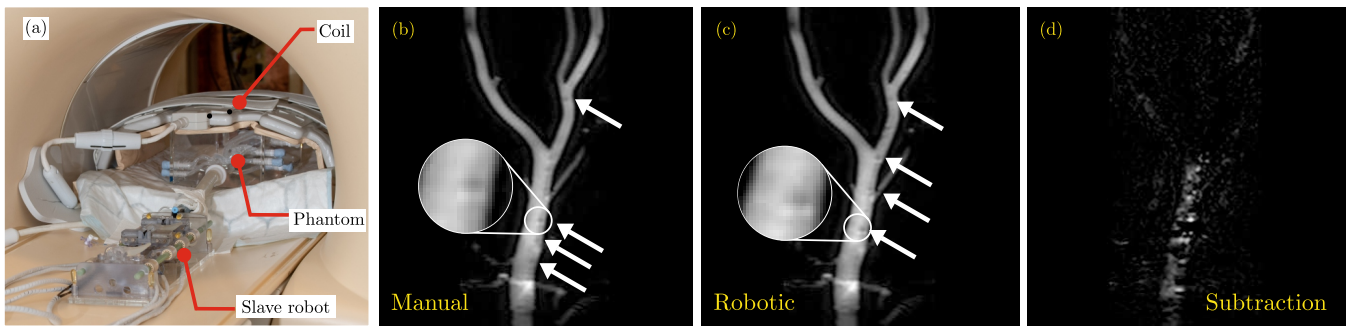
(a) Experimental MRI set-up. Projection of abdominal aorta and iliac arteries with (b) manual and (c) robotic guidewire retraction. Magnified views show the passive MR markers of the guidewire (black spots), (d) Difference image.
